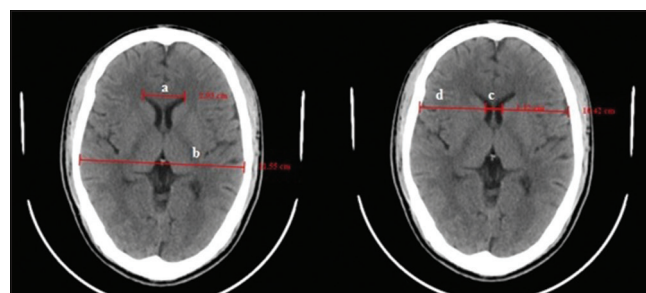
Computed tomography brain axial view a = maximum width of the frontal horns of the bilateral lateral ventricles b = maximum internal diameter of the skull at the same level c = Width of bilateral lateral ventricles at the level of the head of the caudate nucleus d = Distance between inner tables of the skull at the same level
